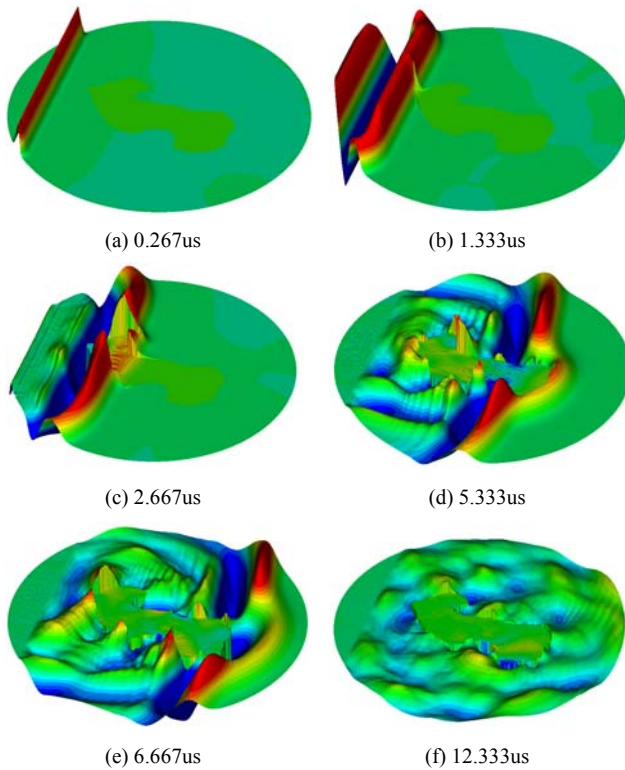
A time-series plot of propagating ultrasound waves in water and bone.
